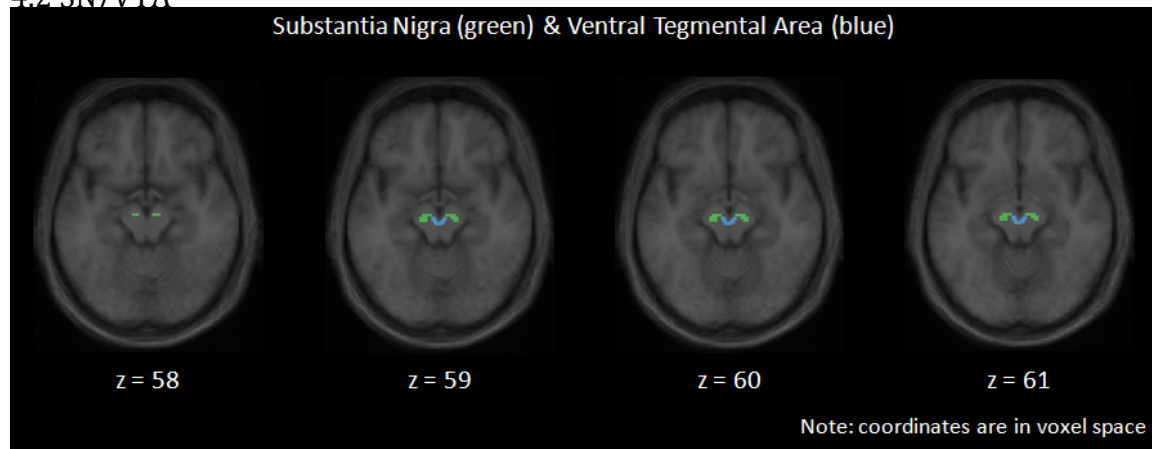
Substantia nigra (SN, green) and ventral tegmental area (VTA, blue) segmentation superimposed on the average MRI in STX space of the 12 participants. SN was defined as in Gravel ⁽¹⁶⁾. Using the SN as a guideline, the VTA was drawn manually based on Blumenfeld (2010).
